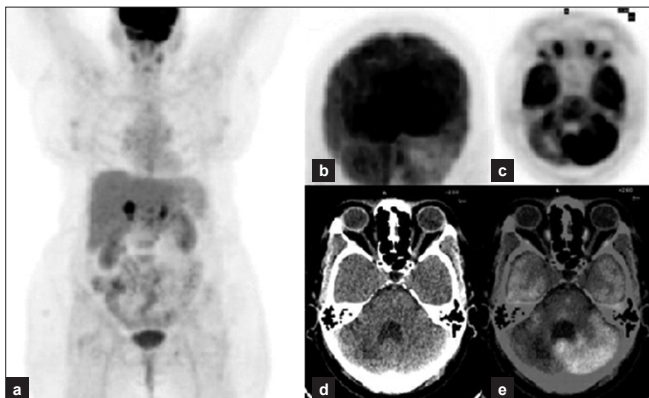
45-year female Ca breast operated for brain mets undergoing chemo for adrenal mets; (a) Anterior MIP image showing hyper-metabolic foci in both adrenal regions; (b, c, d, e) Posterior MIP of the brain, Axial plain PET, CT and fused PET/CT images reveal hypometabolism in the right cerebellar hemisphere corresponding to a hypodense area on LDCT which corresponded to the site of metastectomy
